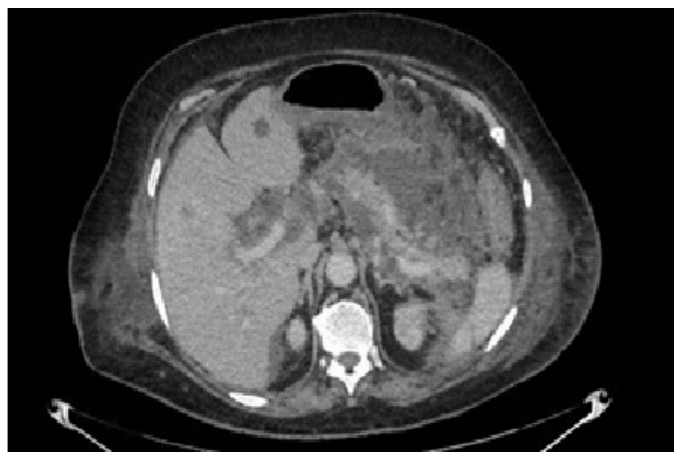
Abdominal CT scan. There is an increased density of peripancreatic fat with peripheral enhancement, in relation to a collection with necrotic tissue up to 12 cm in the major axis.
